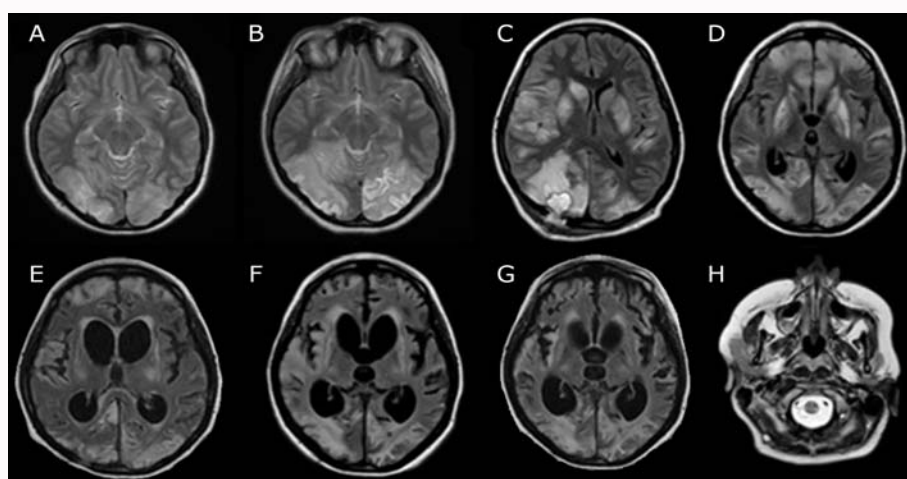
Serial brain MRI findings showing the progressive changes: A) T2-weighted image on day 7 showed increased intensity in the subcortical and deep white matter in both occipital lobes and in the right cortical frontal lobe, with mild mass effect; B) T2-weighted image on day 21 highlighted progressive involvement of cortical-subcortical occipital, parietal and temporal lobes; C) T2-weighted image on day 44 showed swelling of basal ganglia and further progressive extension of areas of high signal in parietal and frontal lobes, mark of right parietal minicraniotomy for brain biopsy; D) T2-weighted image on day 80 showed new high signal of temporal and frontal lobes associated with initial atrophic evolution, E,F) FLAIR -weighted image on day 122 and on day 178 showed progression of cortical-subcortical atrophy with enlargement of the lateral ventricles; G) FLAIR-weighted image on day 232 high signal in left frontal and temporal lobes, H) T2-weighted image on day 264 showed new altered signal in the occipital lobe, right hemisphere cerebellar and focal lesion in bulb and pons.
